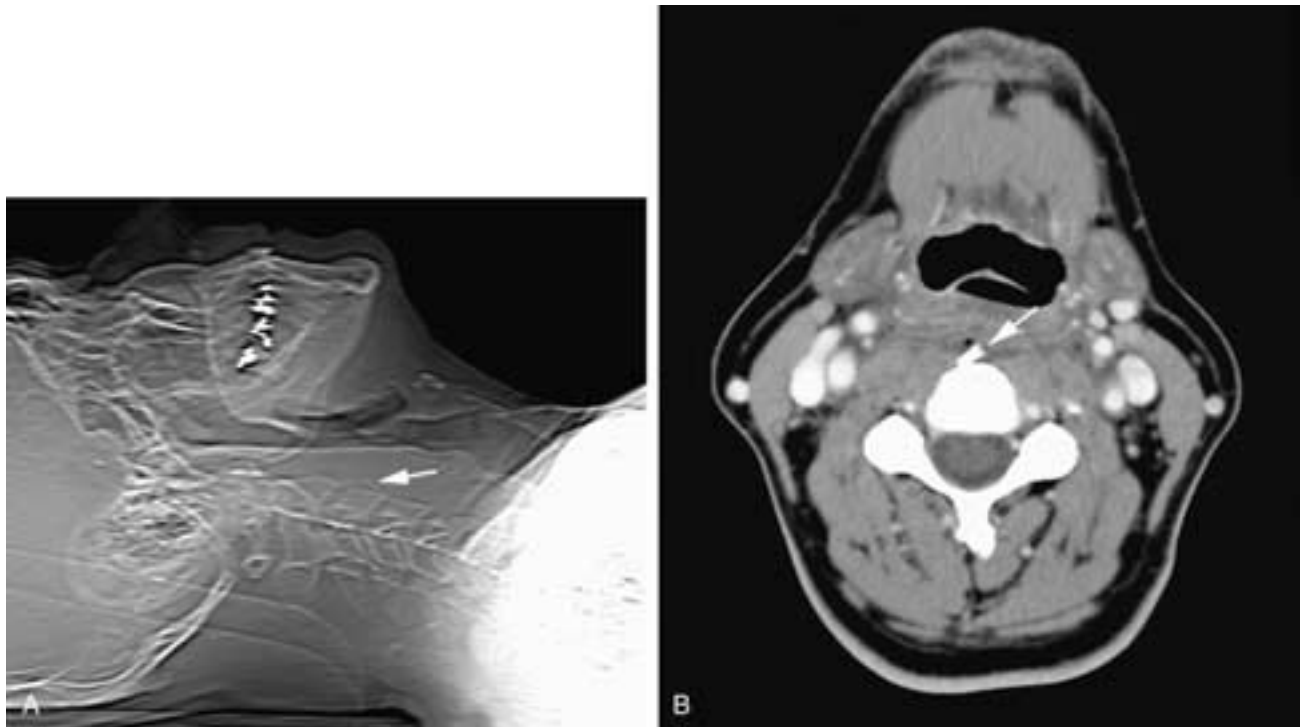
Lateral scout film (A) and axial contrast-enhanced CT scan (B). In A, there is marked thickening of the prevertebral soft tissues and flattening of the mucosal surface. A radiodense foreign body (arrow) is seen anterior to the C3 vertebral body. In B, the foreign body is well seen (arrow) with adjacent air and a water density phlegmon in the retropharyngeal space. In this patient, the foreign body was a flounder fish bone.
